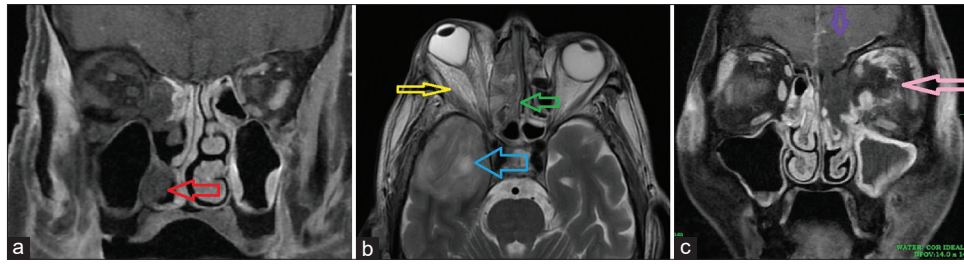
(a) MRI image depicting non-enhancement of inferior turbinate representing black turbinate sign as seen in acute invasive mucormycosis. (b) Heterogenous T2-hyperintense area in the right temporal lobe suggestive of evolving abscess (blue arrow) with extraocular muscle involvement, retro-orbital fat stranding, proptosis, and deformed globe, suggestive of orbital cellulitis (yellow arrow). Right-sided ethmoid air cells have T2-hypointense areas suggestive of fungal sinusitis (green arrow). (c) Image showing infiltration of medial wall of left orbit with extension into orbit with orbital fat stranding (pink arrow) and involvement of extraocular muscles. Non-enhancing left optic nerve with diffusion restriction is seen. The image shows contiguous infection from the sinus cavity into the frontal lobe, indicating destruction of the cribriform plate. Left frontal infarct secondary to the spread of infection via cribriform plate (purple arrow) is seen. MRI = magnetic resonance imaging
